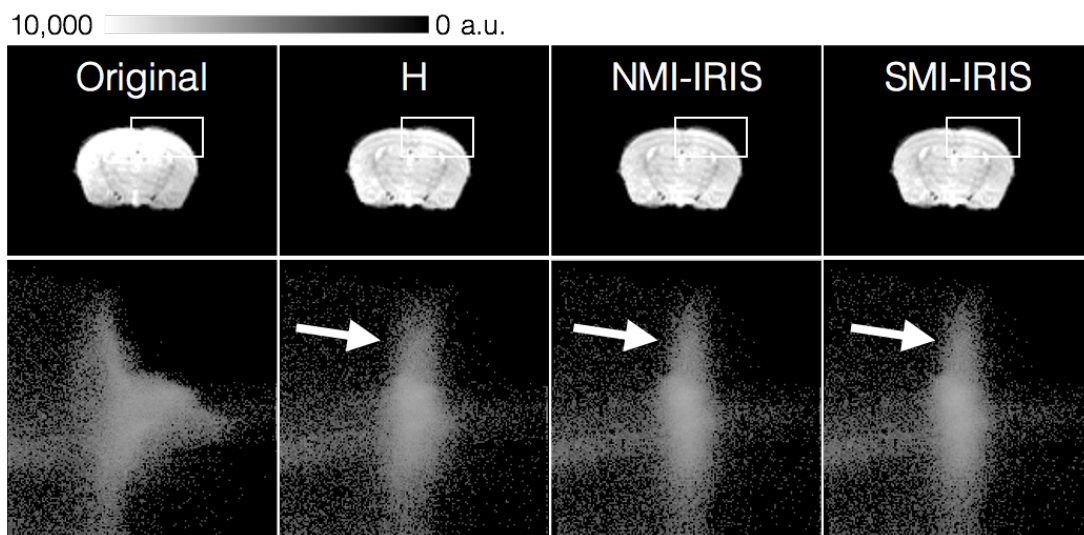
On the top row, axial planes of original IIH-corrupted MRI and corrected images are shown. A white box is placed on an area of the cortex where IIH remains after H minimization correction, but is less apparent after IRIS correction. The bottom row shows corresponding joint histograms at gold standard alignment with their manually registered PET image pair. White arrows show areas of higher intensity correspondences in IRIS-corrected images than in the H-corrected image.
